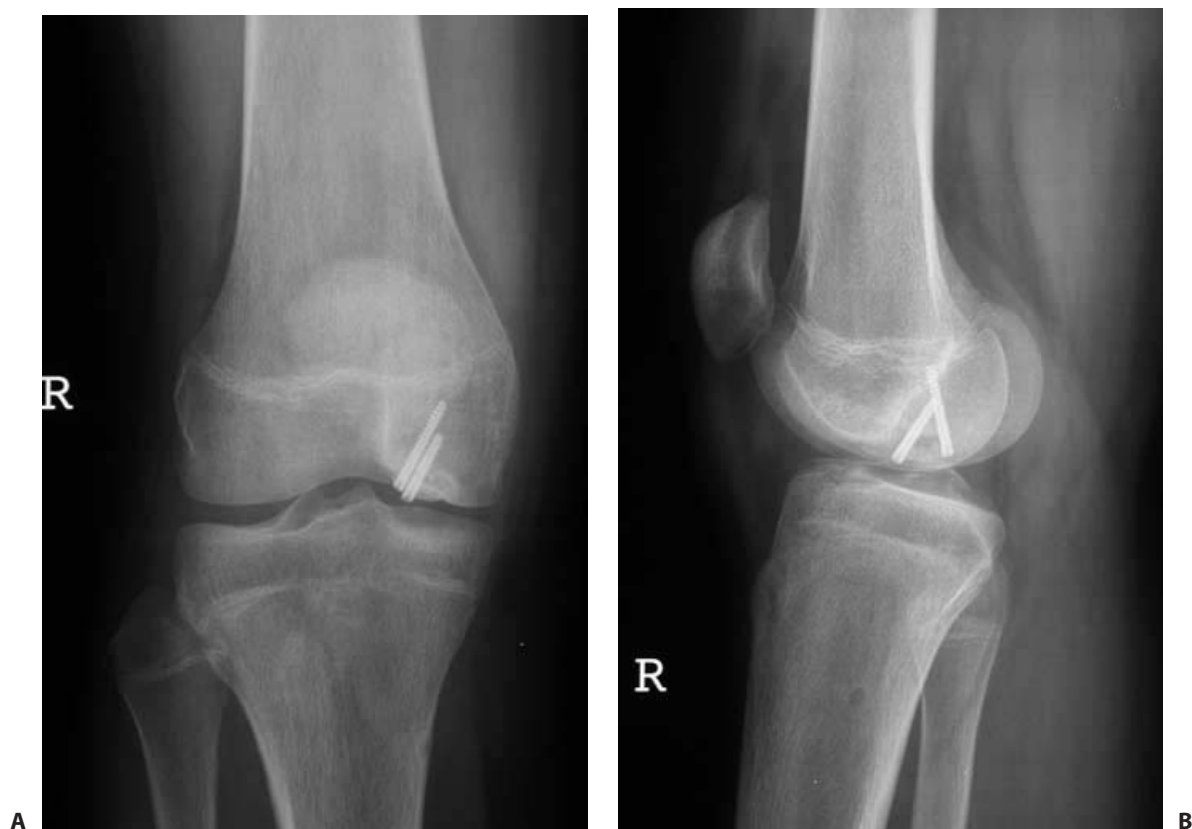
Anteroposterior (A) and lateral (B) radiographs obtained 8 weeks postoperatively demonstrate excellent healing of the fragment with no evidence of displacement.
